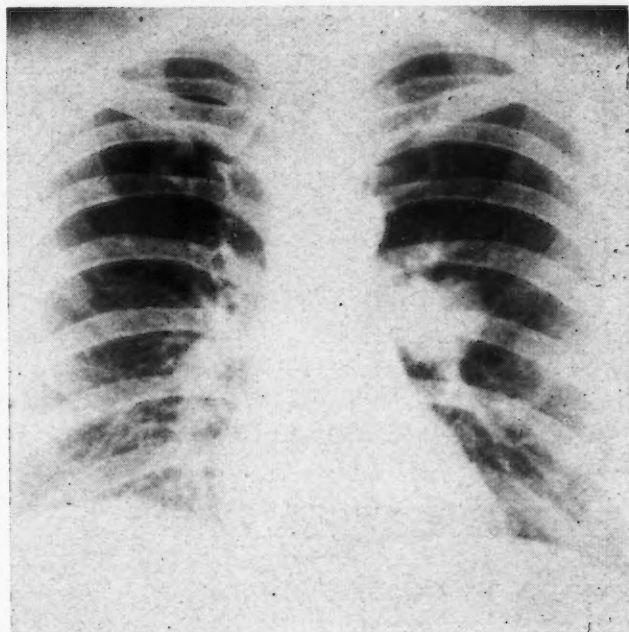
Chest roentgenogram of benign lymphoid tumour of left lower lobe.
